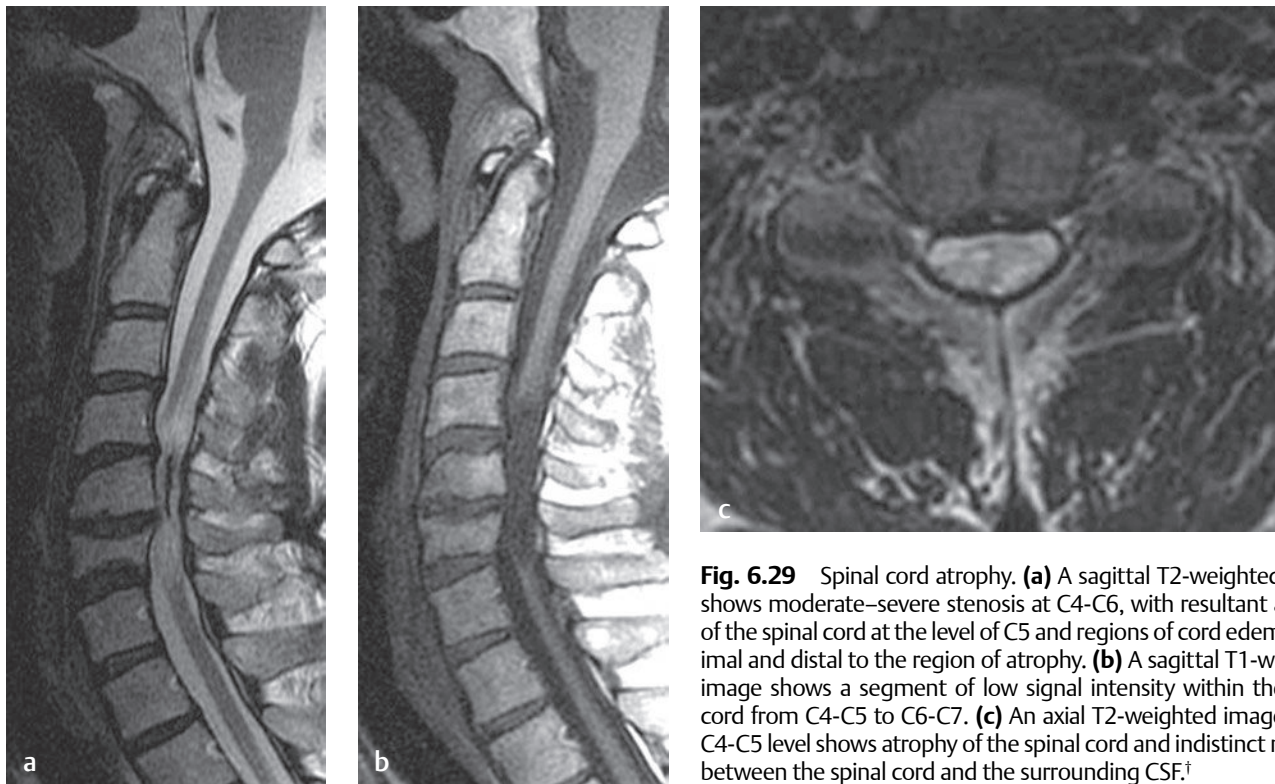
Spinal cord atrophy. (a) A sagittal T2-weighted image shows moderate-severe stenosis at C4-C6, with resultant atrophy of the spinal cord at the level of C5 and regions of cord edema proximal and distal to the region of atrophy. (b) A sagittal T1-weighted image shows a segment of low signal intensity within the spinal cord from C4-C5 to C6-C7. (c) An axial T2-weighted image at the C4-C5 level shows atrophy of the spinal cord and indistinct margins between the spinal cord and the surrounding CSF.[†]
